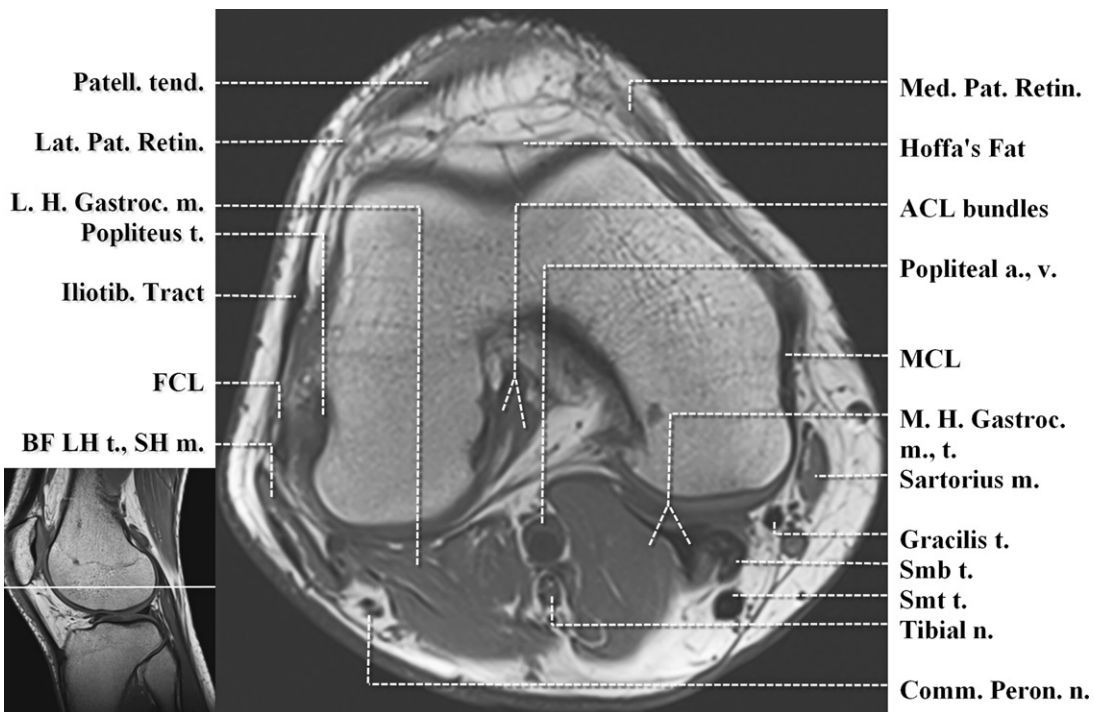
Axial T1-weighted image. Inferior patellofemoral compartment. a., artery; ACL, anterior cruciate ligament; BF LH. t., SH m., biceps femoris short head muscle, long head tendon; Comm. Peron. n., common peroneal nerve; FCL, fibular collateral ligament; Iliotib., iliotibial; m., muscle; MCL, medial collateral ligament; M.H./L.H. Gastroc., medial and lateral heads of gastrocnemius; Med./Lat. Pat. Retin., medial and lateral patellar retinacula; n., nerve; Patell. tend., patellar tendon; Smb, semimembranosus; Smt, semitendinosus; t., tendon; v., vein.
